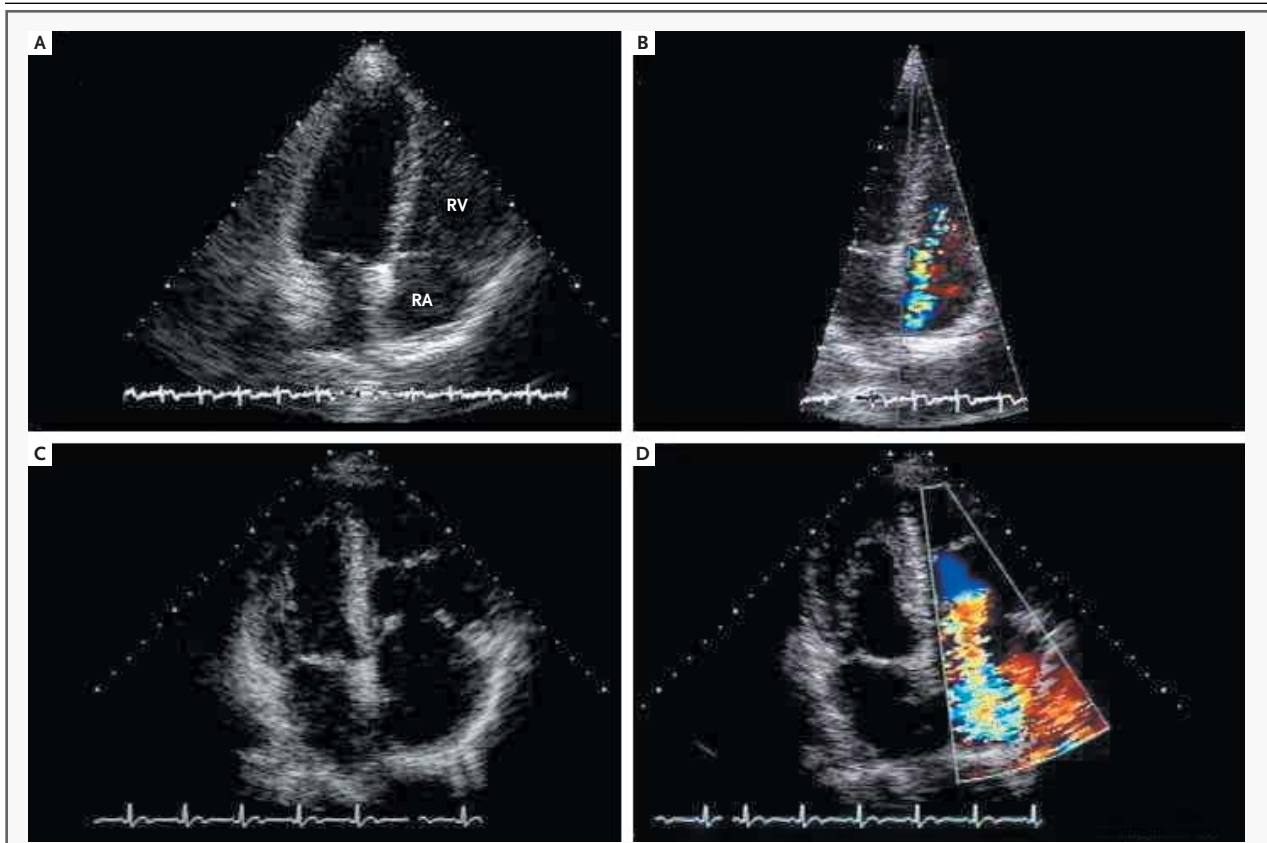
Example of Serial Echocardiographic Studies Showing an Increase in the Cardiac Score of More Than 25 Percent.
